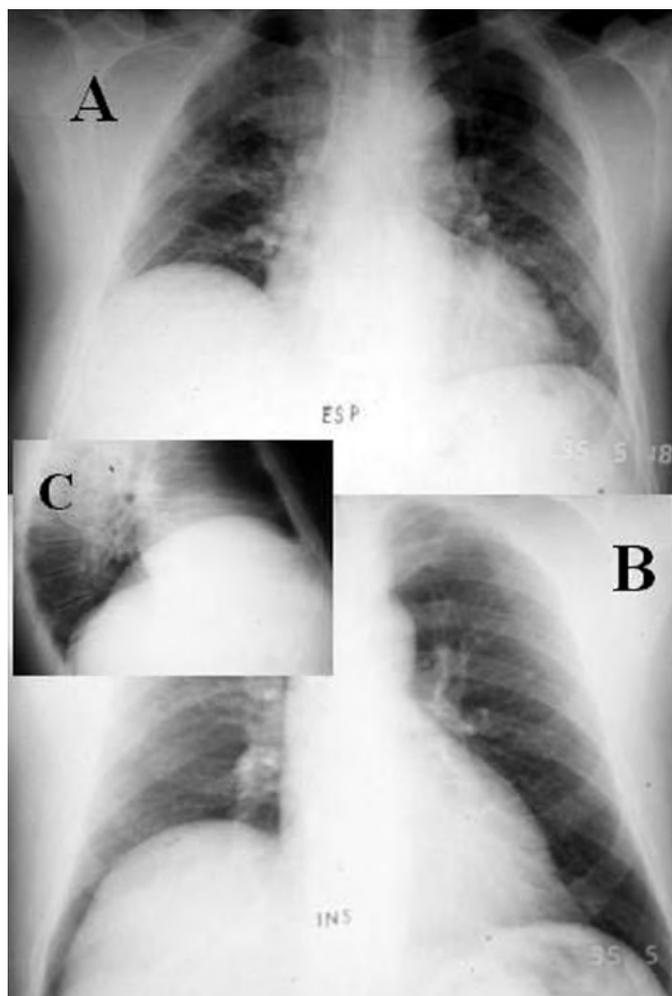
Pre operative X-ray. Confronting inhalation and expiration both the raising of the right diaphragmatic dome (A) and the exaggerated widening of the right costo-phrenic sinus (B) become evident, without equivalent lowering of the dome, lowering of the dome, that remains high located (C).
